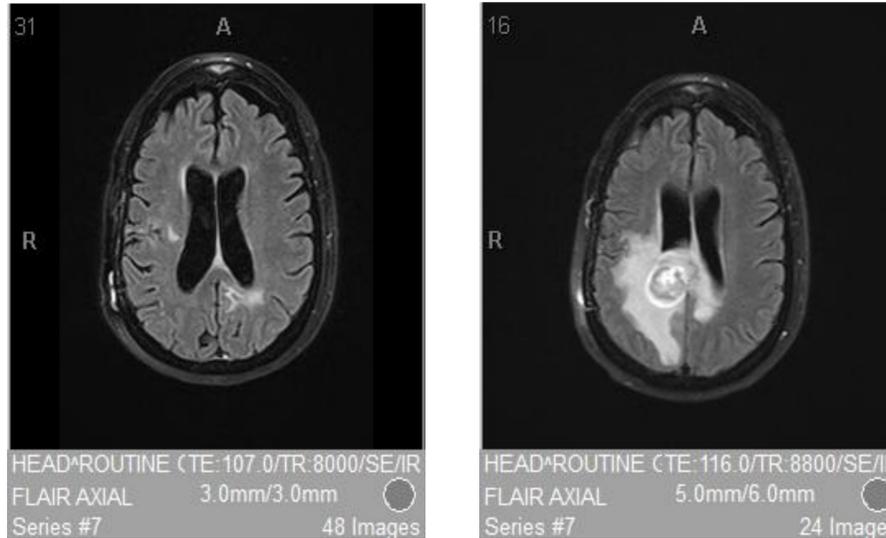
Comparison of MRI brain with IV contrast 5 months apart. MRI brain (left) demonstrates significantly improved left posterior callosal lesion from initial presentation while on cyclophosphamide. On presentation, MRI brain (right) with new enhancing mass-like lesion in the right corpus callosum. Thought to likely be an additional area of vasculitis with associated inflammation, however, CNS lymphoma could have a similar appearance
